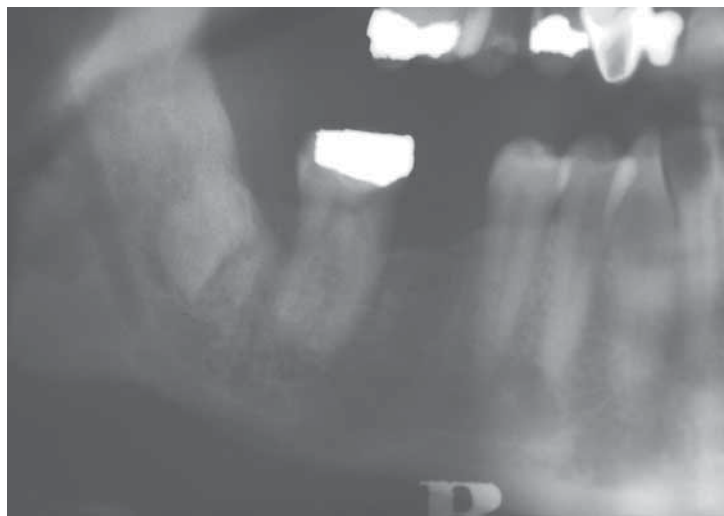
Further post-operative radiograph at 33 months demonstrating further favourable migration of the roots of the lower third molar with signs of partial obliteration residual pulp chamber.
